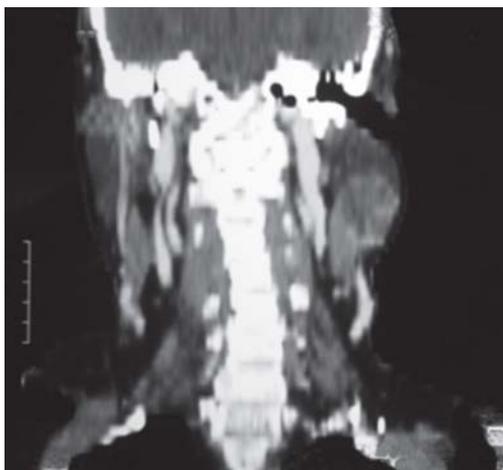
CT neck-coronal section showing lesion in relation to left parotid gland
